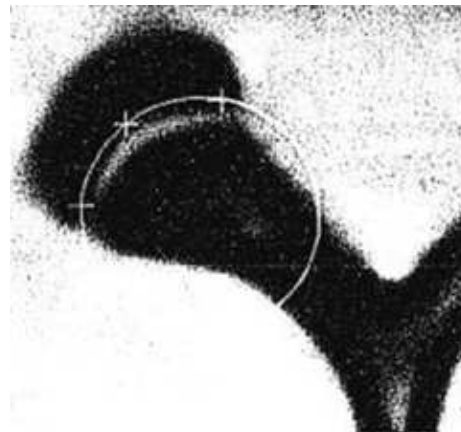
CT scan image with FCC drawn through reference points. Adapted from van Schaik and van Pinxteren (1999).
